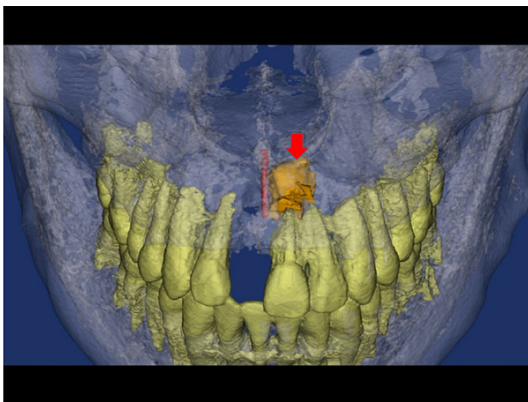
CBCT 3D reconstruction of the case. In the view of the 3D reconstruction of CT by mimics software, teeth, bone, lesion as well as the nasopalatine nerve canal are segmented out with different colors.
